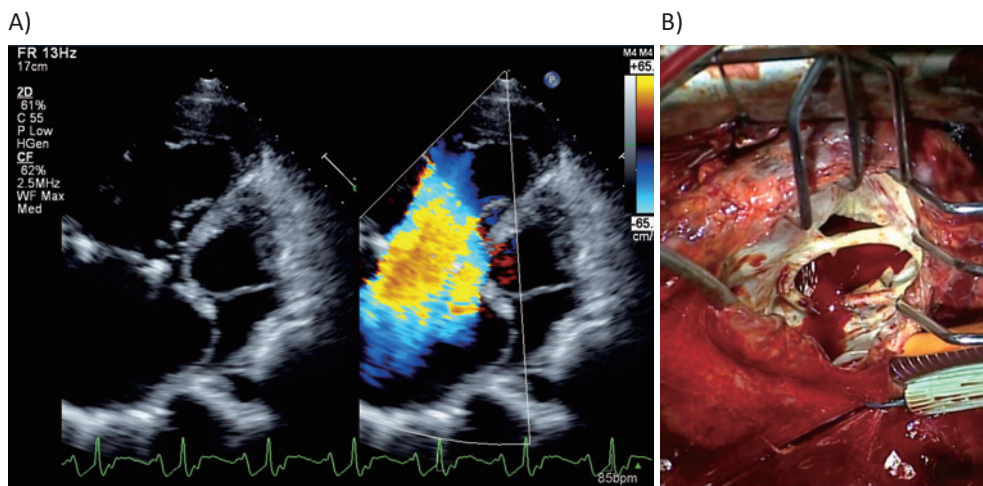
The tricuspid valve and right heart in a preoperative cardiac echocardiogram (A) and in an operative photograph (B).
